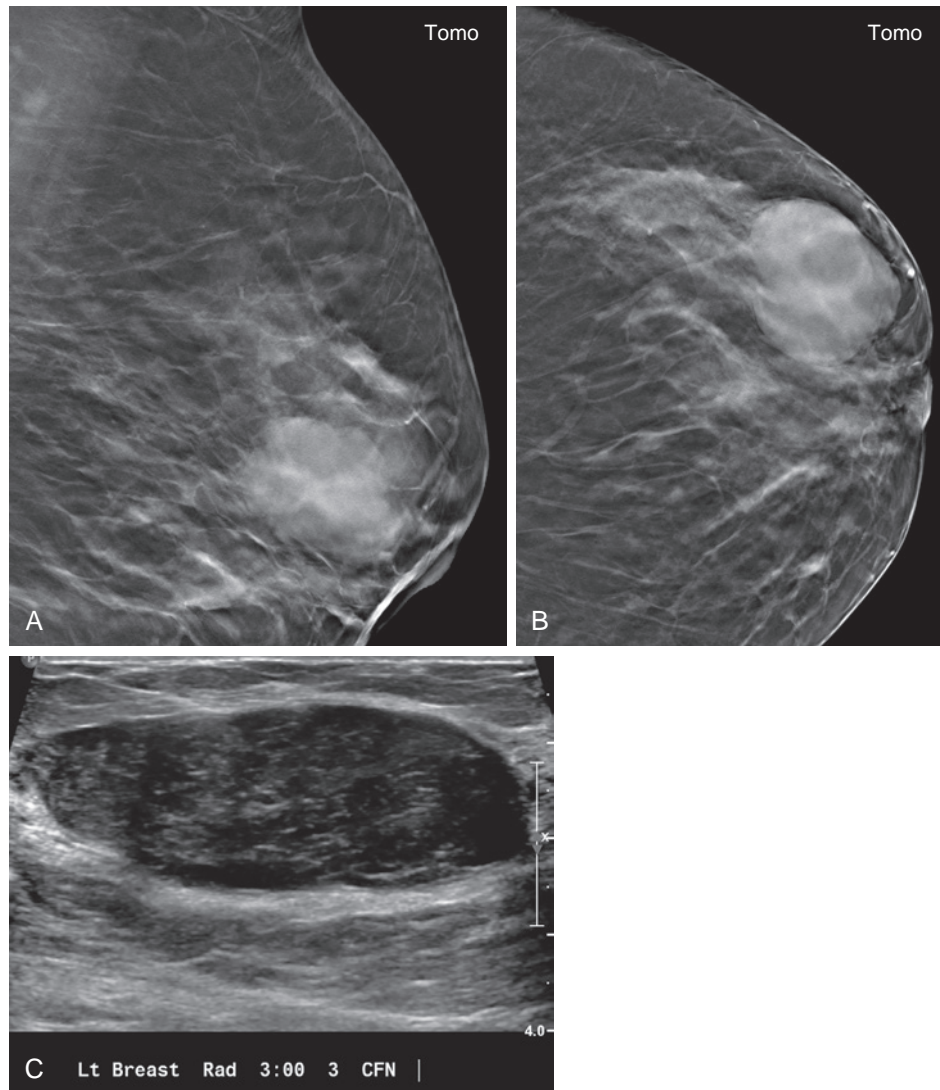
Phyllodes tumor. A 54-year-old woman presented for screening mammography. Tomosynthesis images in mediolateral oblique (A) and craniocaudal (B) projection show a 5.4-cm mass in the left breast at the 3-o'clock position, which was new since the prior mammogram performed 16 months earlier. (C) Targeted ultrasound reveals a corresponding circumscribed, oval, hypoechoic mass. The patient ultimately had the mass surgically excised, yielding a benign phyllodes tumor.
